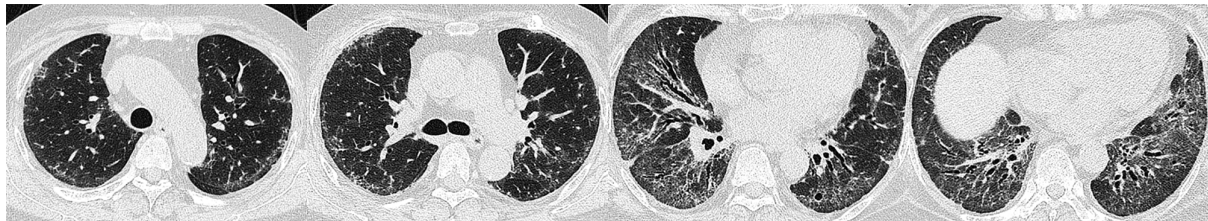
A 56-year-old woman with a 2-year history of dry mouth and a 2-day fever with a diagnosis of primary Sjögren's syndrome (pSS). On CT images, ground-glass shadows and grid shadows are observable in both lungs. These are distributed asymmetrically and mainly under the pleura. The lower lung is larger than the upper lung, accompanied by traction bronchiectasis.
